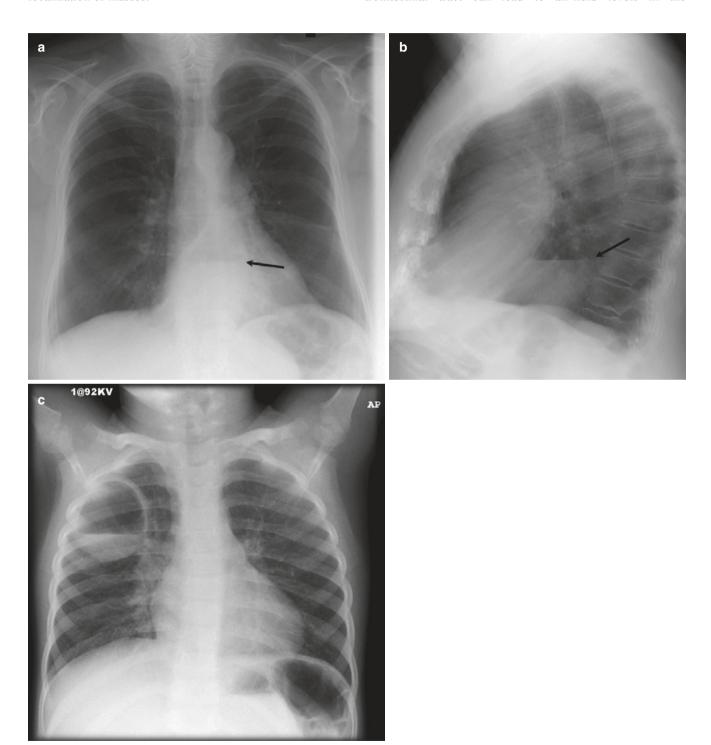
Air-fluid level. (a, b) Frontal and lateral chest radiographs show retrocardiac opacity with air-fluid level (arrow), suggestive of a hiatal hernia. (c) Lung abscess
